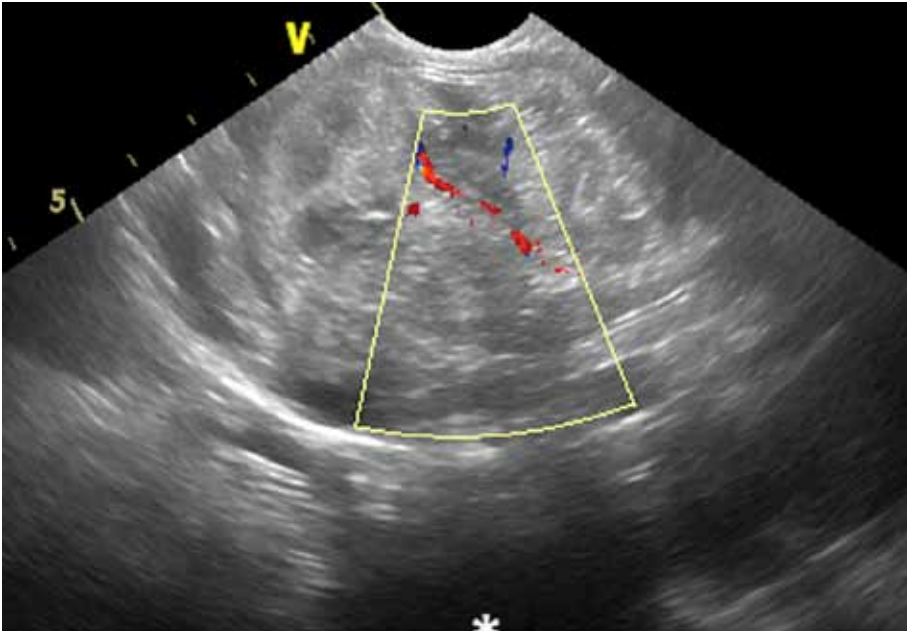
Colour Doppler examination of the pylorogastric intussusception confirmed blood flow in vessels of the intussuscepted segment of the stomach.
